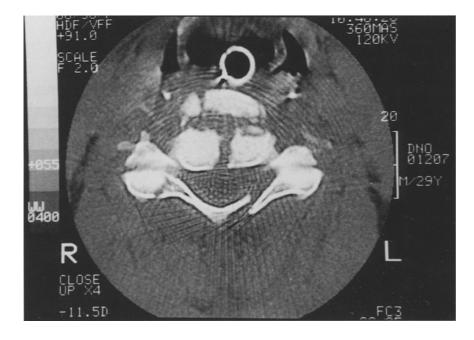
CT scan of cervical spine of patient
